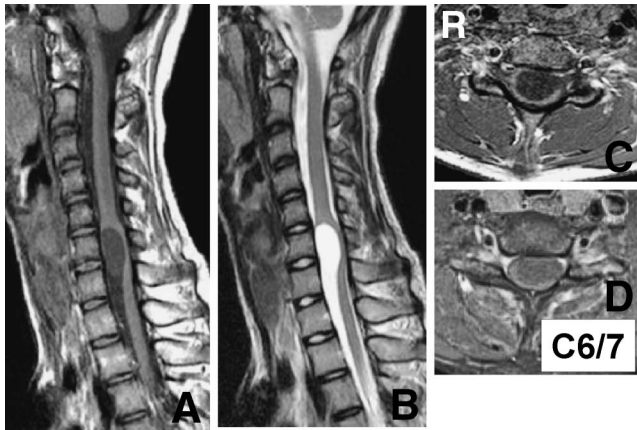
A, B: Cervical sagittal magnetic resonance (MR) images showing the intradural cystic lesion at the C6-7 level appearing as low signal intensity on the T₁-weighted image (A) and high signal intensity on the T₂-weighted image (B). C: Cervical axial T₁-weighted MR image showing the intradural cystic lesion at the C6-7 level appearing as low signal intensity. The cyst is positioned anteriorly, and caused significant symmetrical dorsal shortening and thinning of the spinal cord. D: Cervical axial T₁-weighted MR image with gadolinium showing a slightly enhanced intradural cyst.
